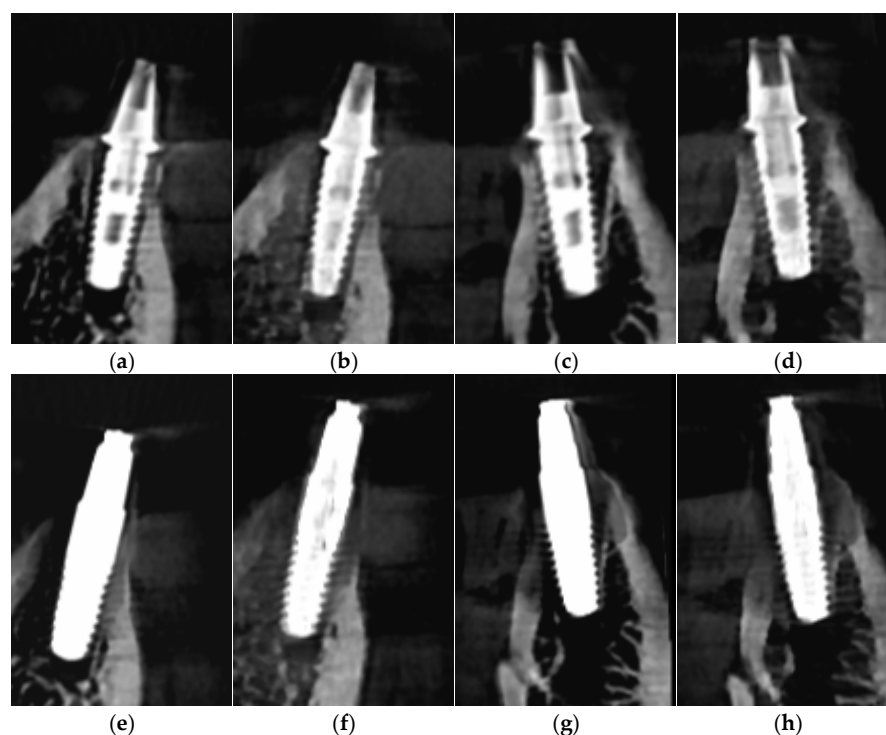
Cross-sectional CBCT images depicting (a) small fenestration defect adjacent to a titanium implant in MAR Off mode; (b) small fenestration defect adjacent to a titanium implant in MAR On mode; (c) small dehiscence defect adjacent to a titanium implant in MAR Off mode; (d) small dehiscence defect adjacent to a titanium implant in MAR On mode; (e) small fenestration defect adjacent to a zirconia implant in MAR Off mode; (f) small fenestration defect adjacent to a zirconia implant in MAR On mode; (g) small dehiscence defect adjacent to a zirconia implant in MAR Off mode; and (h) small dehiscence defect adjacent to a zirconia implant in MAR On mode.
